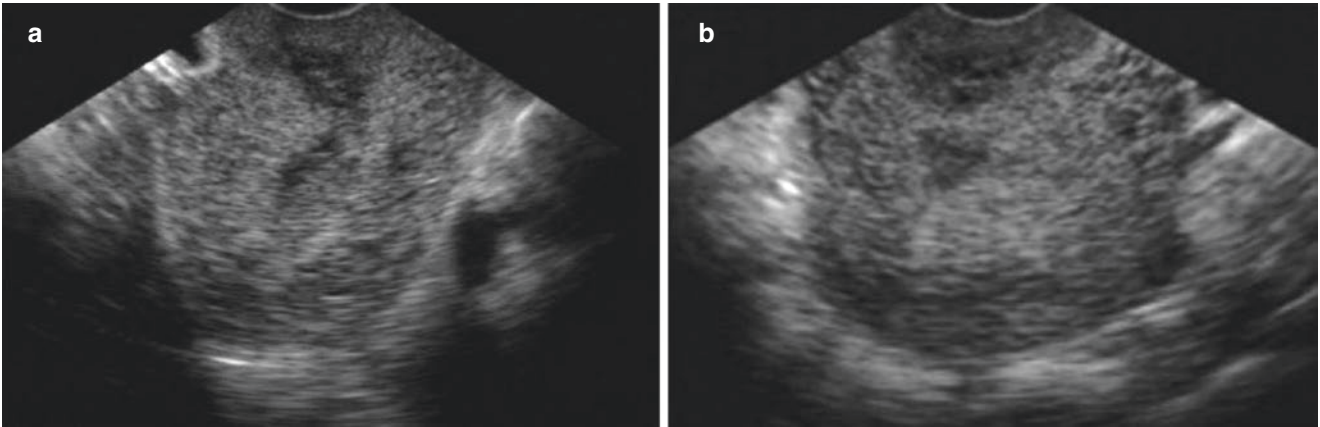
Endometritis. (a, b) Ultrasonography shows a slightly enlarged uterus, hypoechoic, and thickened endometrium
